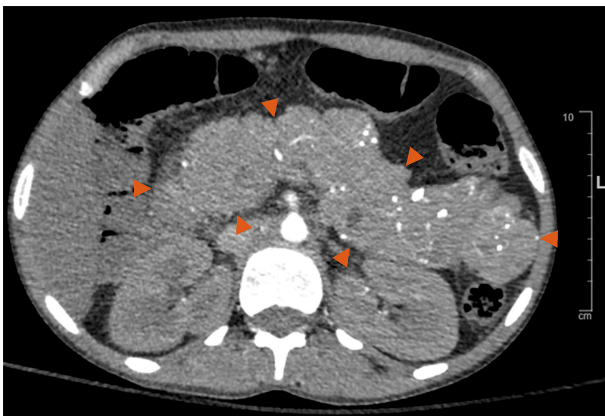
Pancreas in Mahvash disease, axial view of computed tomography with enhancement. Note the enormously and evenly enlarged pancreas with normal pancreatic contour. Also note the multiple punctate calcifications in the pancreas.
